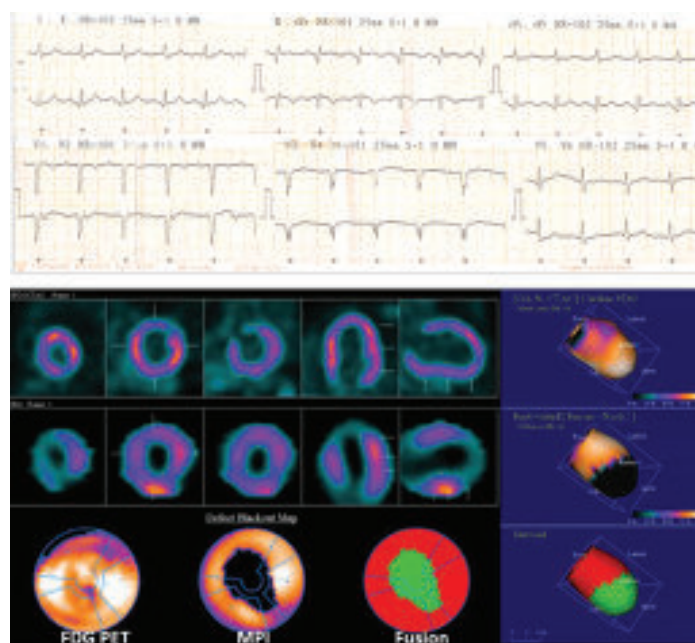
(case 4): A 52 years male patient having old anteroseptal and inferior MI with critical TVD, DM, dyslipidemia and severe LV systolic dysfunction on echocardiogram (LVEF:33%). MPI and PET fusion imaging revealed large area of perfusion-metabolism mismatch defect in the triple vessel territory involving apex, apical to mid anterior, anteroseptal and inferolateral wall signify hibernating / viable myocardium & good chance of improvement after revascularization. Small area of perfusion-metabolism mild reverse mismatch defect (stunned myocardium) in basal anterior wall- suggesting dysfunctional viable myocardium. Patient underwent CABG and significant clinical improvement was seen in subsequent follow up.
